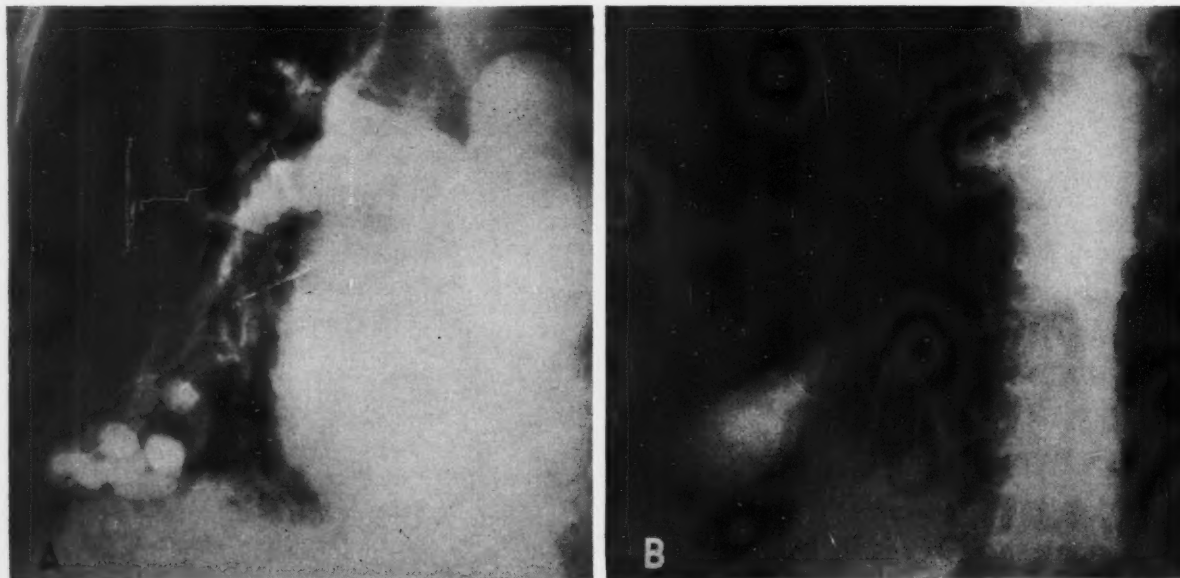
Pulmonary arteriovenous fistula:* A, frontal angiocardiogram at 4.0 seconds. A sixty-seven year old female (N.Y.H. 319 819) with rheumatic heart disease of many years' standing. The diagnosis was made on the basis of a conventional chest x-ray, strengthened by the demonstration of a bruit at the right base and proved by angiocardiography. B, frontal angiocardiogram at 5.0 seconds. The patient, a thirty-nine year old woman (N.Y.H. 596 001), was admitted for a brain abscess which was treated surgically. Chest x-ray showed a rounded mass in the right lower lobe with communicating vascular shadows. Diagnosis confirmed by opacification of the arteriovenous fistula which was fed by a branch of the posterior basal segmental artery and drained into the left atrium through a large pulmonary vein.
